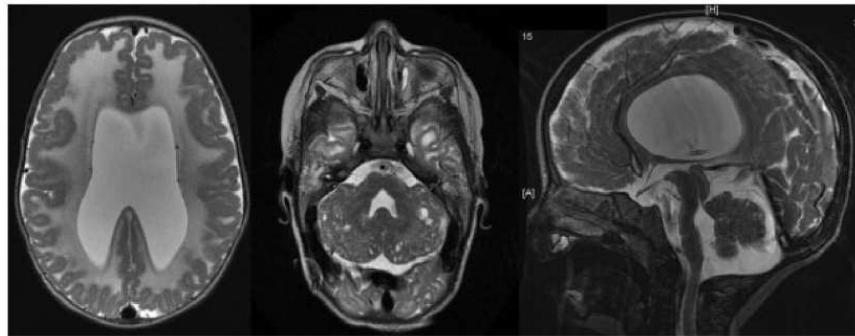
T2-weighted images in transverse, coronal, and sagittal planes of a 5-month-old (Patient 19) with *POMGnT1* mutations. There is widespread polymicrogyria in frontal and parietal lobes, and abnormal high signal intensity throughout the white matter. There are multiple cysts in the hypoplastic cerebellar hemispheres in the transverse view. There are clefts in the dorsal and ventral pons. In the sagittal plane, the pons is thinned with a concave posterior border, and the midbrain tectum is abnormally large.
